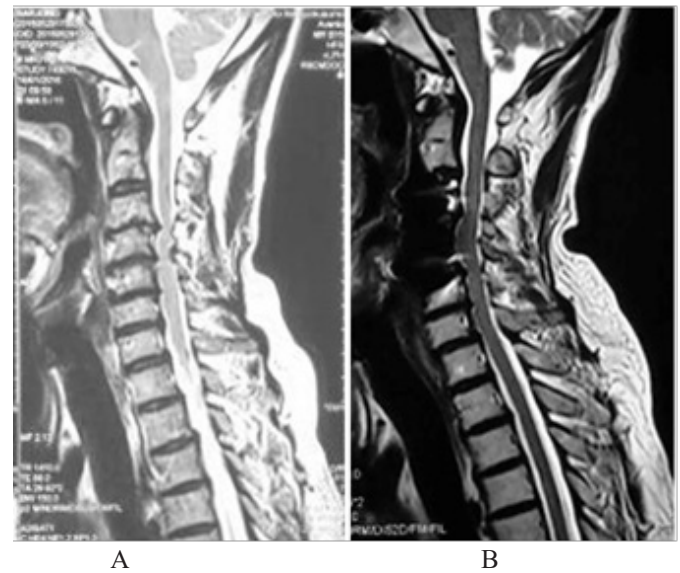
Preoperative and postoperative cervical MRI images. Notes: (A) Preoperative MRI image showing the cord was compressed with "bead-like" shape. (B) Postoperative MRI image showing the compression of the cord was almost completely removed. Abbreviation: MRI, magnetic resonance imaging.
